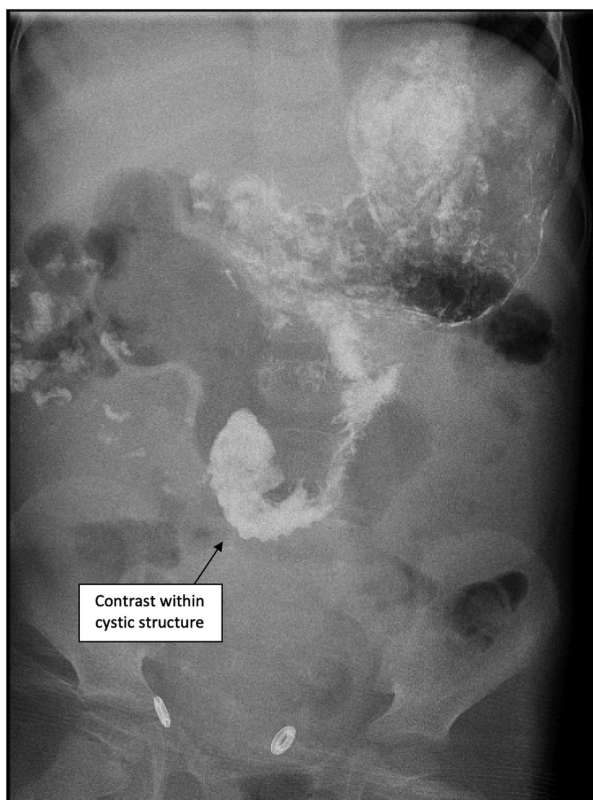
Post-contrast abdominal x-ray—showing contrast within the cystic structure.
